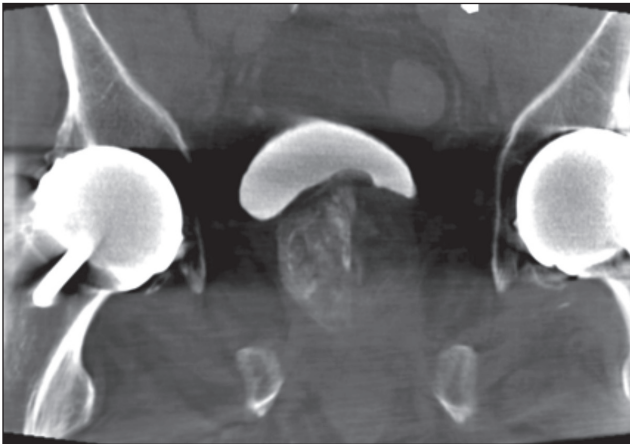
Coronal image from a noncontrast cone-beam CT after embolization, demonstrating retained contrast throughout the prostate. The increased density seen in the right hemi-prostate is due to the fact that it was embolized after the left and, therefore, less of the contrast had been resorbed.
